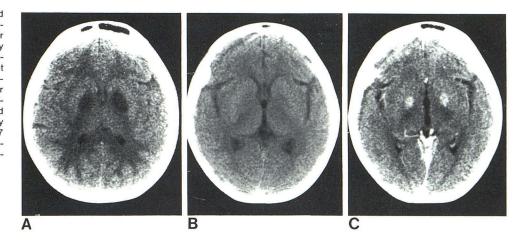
Case 3, 39-year-old alcoholic man found pulseless on street. A, Unenhanced CT scan 2 days after admission. Subtle areas of low density in caudate bilaterally (*arrows*), effaced sulci, and loss of normal differentiation of gray-white matter (cf. fig. 6). B and C, Contrast-enhanced CT scans 14 days later. Marked, diffuse enhancement of deep cortex and of basal ganglia. Sulci have returned to normal.
